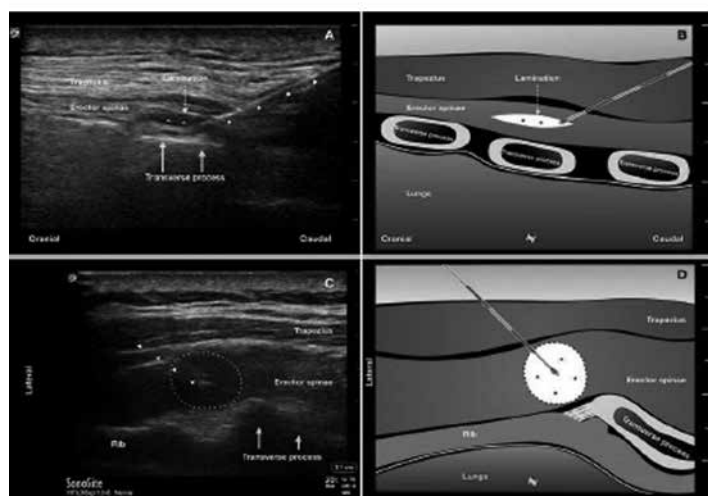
T5 vertebral level parasagittal (A, B) and transverse (C, D) approach to the erector spinae plane block. Needle trajectory indicated by arrow heads. In images A and B, the needle tip is located between the muscle fibers, which run parallel to the ultrasound beam in the parasagittal probe orientation. When fluid is injected here (*), the ultrasound appearance may replicate that seen with an interfascial injection (also known as lamination), but the result will be an intramuscular injection. With a transverse approach, as shown in images C and D, the needle tip is similarly placed intramuscularly. However, injection in this orientation results in localised circumferential spread of fluid (dotted circle), which is less likely to be confused with interfascial spread. Reproduced from Narayanan M, Venkataraju A. Transverse approach to the erector spinae block: is there more? *Reg Anesth Pain Med.* 2019;44:529-530, with permission from BMJ Publishing Group Ltd (license 4615000311499).
